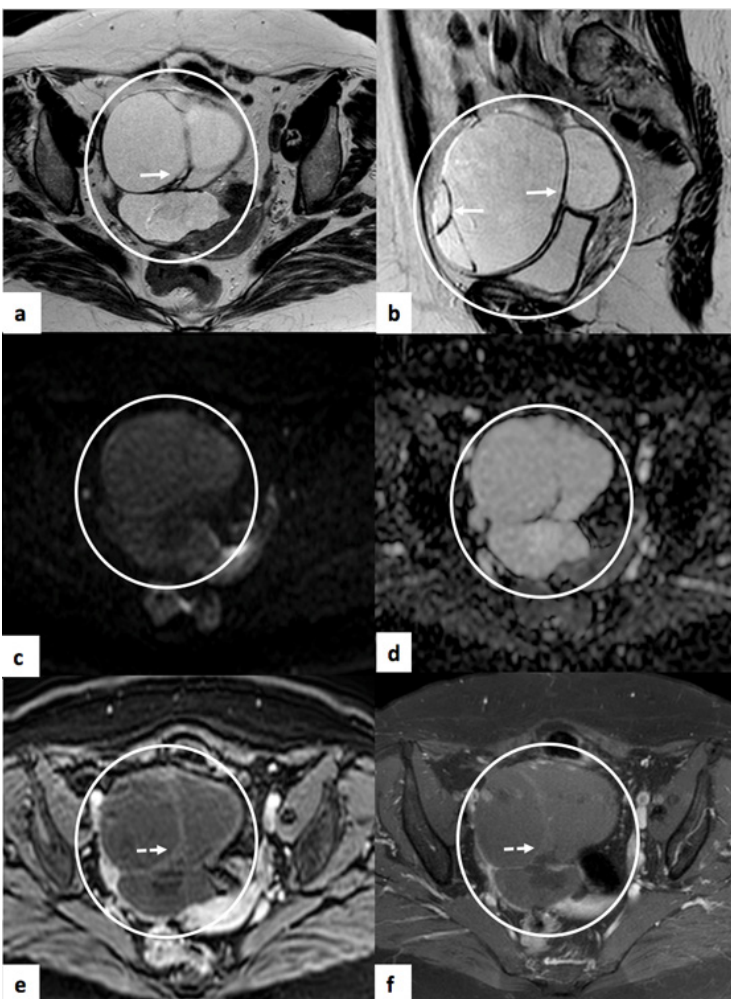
Cystadenofibroma of the right ovary. Pelvic MRI of a 75-year-old woman. (a) and (b) Axial and sagittal T2-weighted images, respectively, showing a large cystic tumour (circle), which shows T2 hypointense septae (arrows). (c) and (d) DWI ($b=1000$) and ADC map, respectively, showing no restricted diffusion. In the study after intravenous contrast - axial T1 SPAIR (e) and in the delayed axial acquisition SPIR (f), there is mild enhancement of the septae (dashed arrows).
